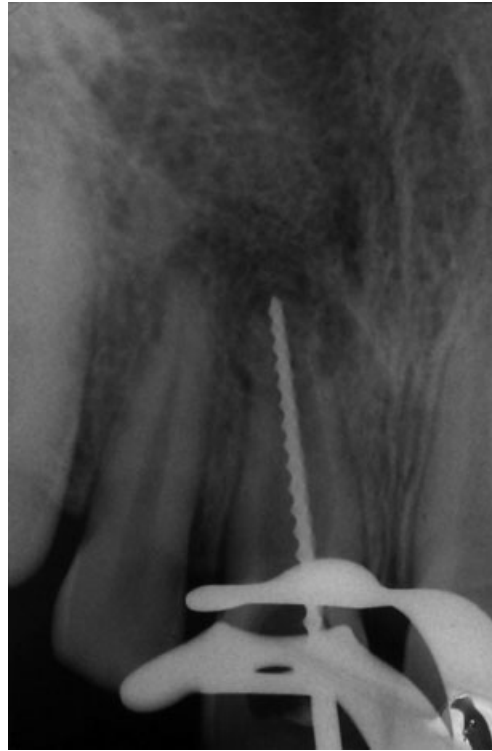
At 120 days, there was reduction in the foraminal opening and the dimension of periapical radiolucency. Note the extrusion of calcium hydroxide paste.
